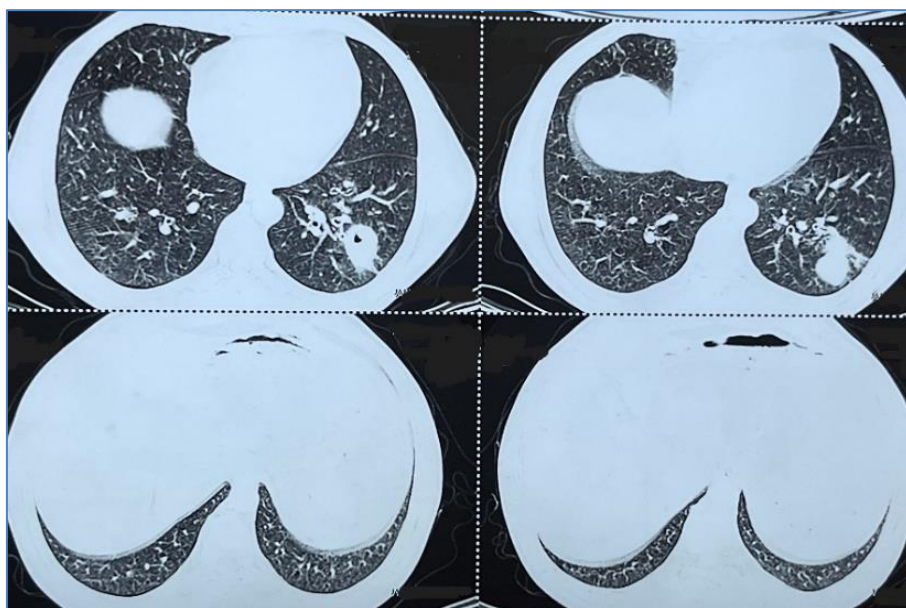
HRCT thorax coin lesion with central lucency or cavitation
